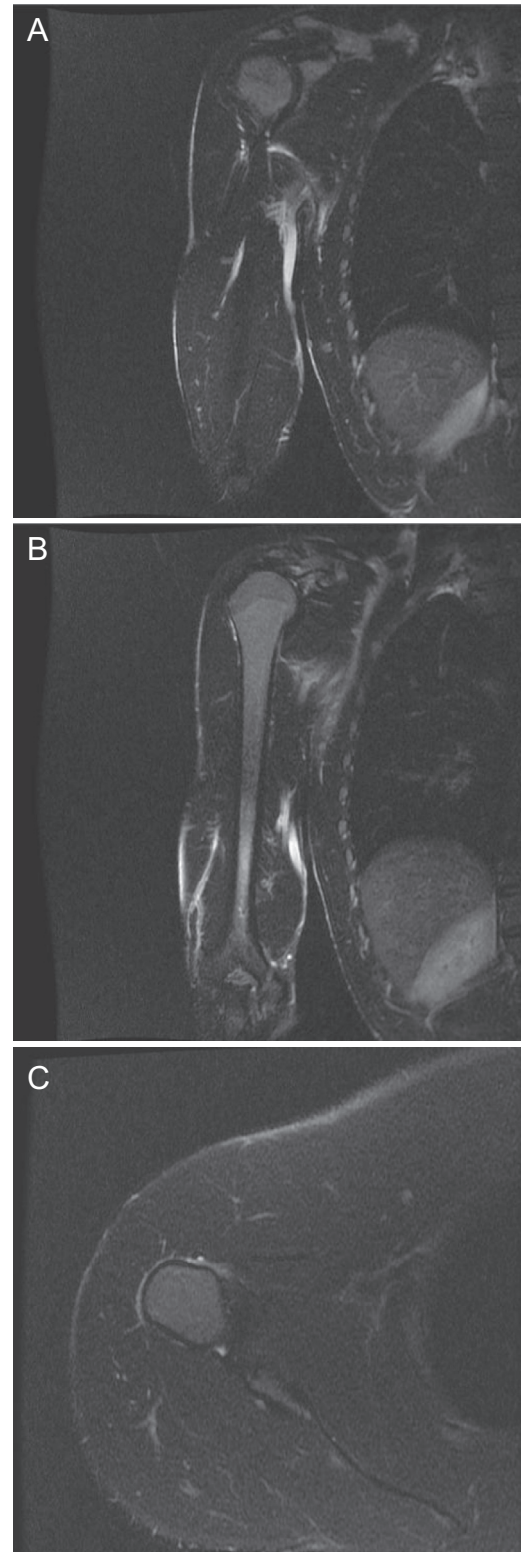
Sequential T2 magnetic resonance imaging cuts in (A,B) coronal and (C) axial views demonstrate absence of latissimus dorsi insertion with intermediate signal suggestive of scar tissue.
